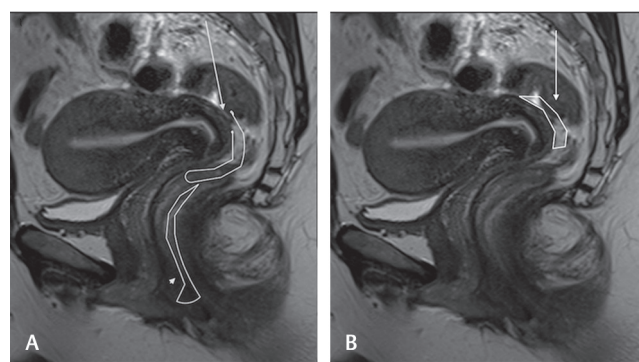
(A, B) T2W sag images showing the recto-vaginal pouch (*arrow* in A), the recto-vaginal septum (*arrowhead* in A), and the retrocervical space (*arrow* in B). T2W, T2-weighted.
